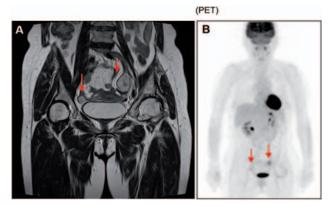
Solid tumor detected by coronal T2-enhanced MRI (A) and PET (B). A solid mass, approximately 35 mm in diameter (*arrow*), was detected in the left abdomen, with a second mass, approximately 15 mm in diameter (*arrow*), detected in the right abdomen.
